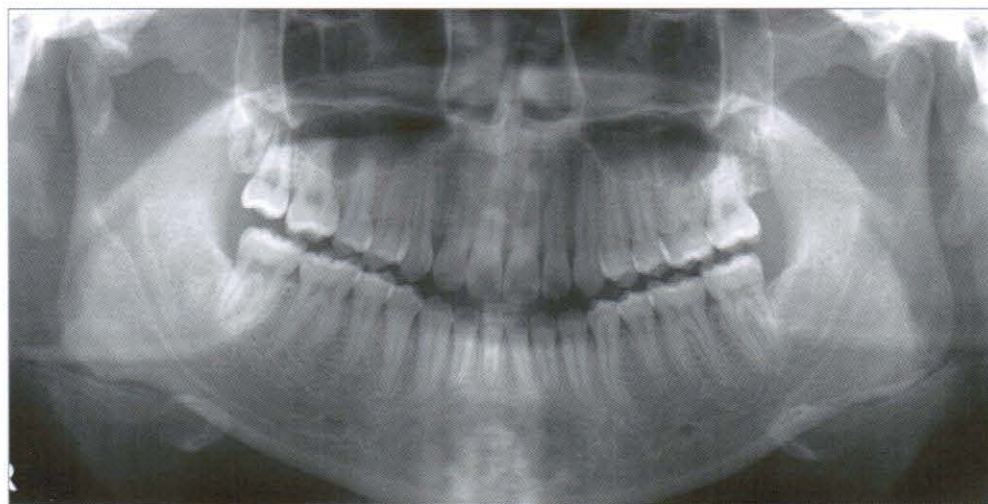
Panoramic radiograph at 1 year retention (2008, 3,21)
